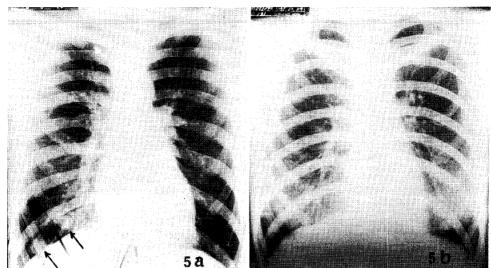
(a) Chest x-ray showing pulmonary metastases of osteogenic sarcoma (arrows). Tomograms revealed multiple bilateral metastases. (b) Three months after therapy, the chest x-ray became normal with no residual lesion.
